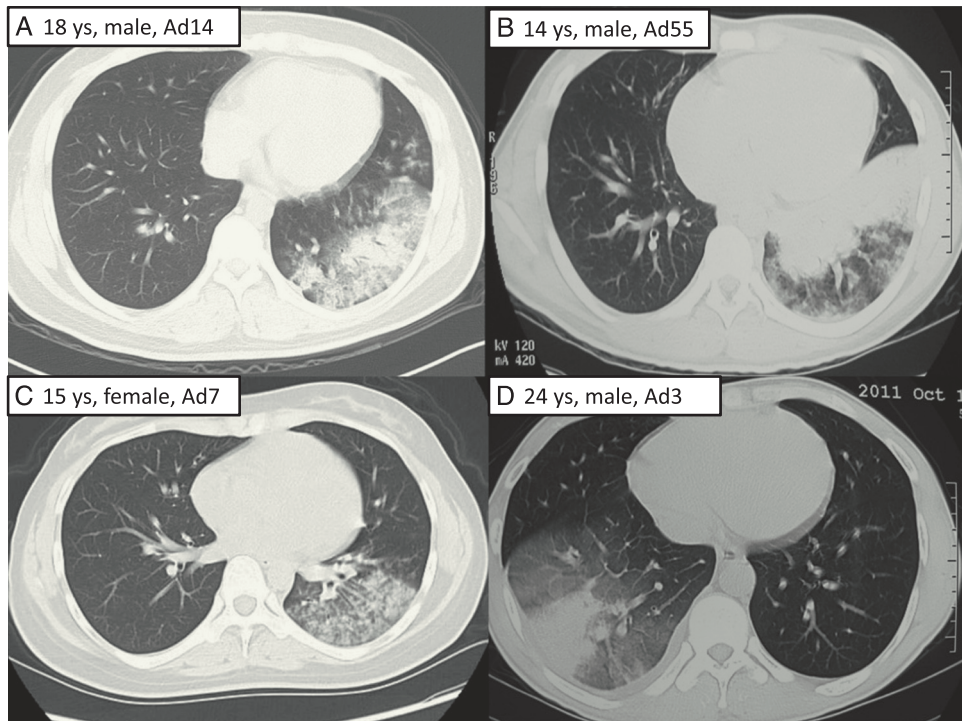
Radiographic findings of four patients infected with different types of adenoviruses. A, An 18-year-old young man infected with human adenovirus (HAdV)-14. Chest CT scan showed patchy infiltrate, ground-grass opacity, and partial consolidation of left lower lobe. B, A 14-year-old boy infected with HAdV-55. Chest CT scan showed consolidation and ground-grass opacity of left lower lobe. C, A 15-year-old girl infected with HAdV-7. Chest CT scan showed patchy infiltrate and ground-grass opacity of left lower lobe. D, A 24-year-old man infected with HAdV-3. Chest CT scan showed consolidation and ground-grass opacity of right lower lobe. ys = years old.
